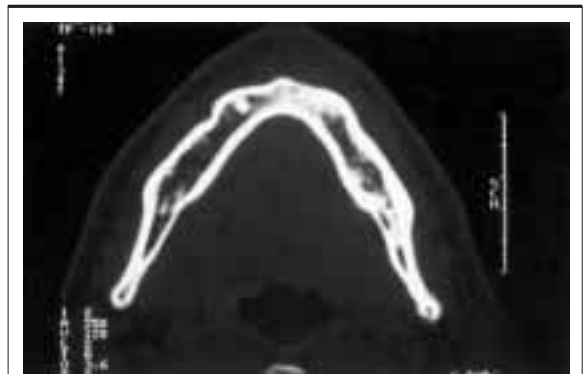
CT of mandible: neoplastic infiltration of mandibular bone.
